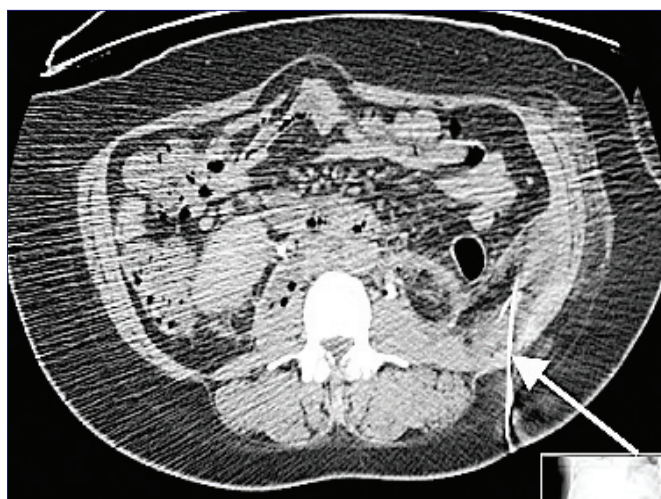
CT without contrast – drain insertion into left retroperitoneal collection.
